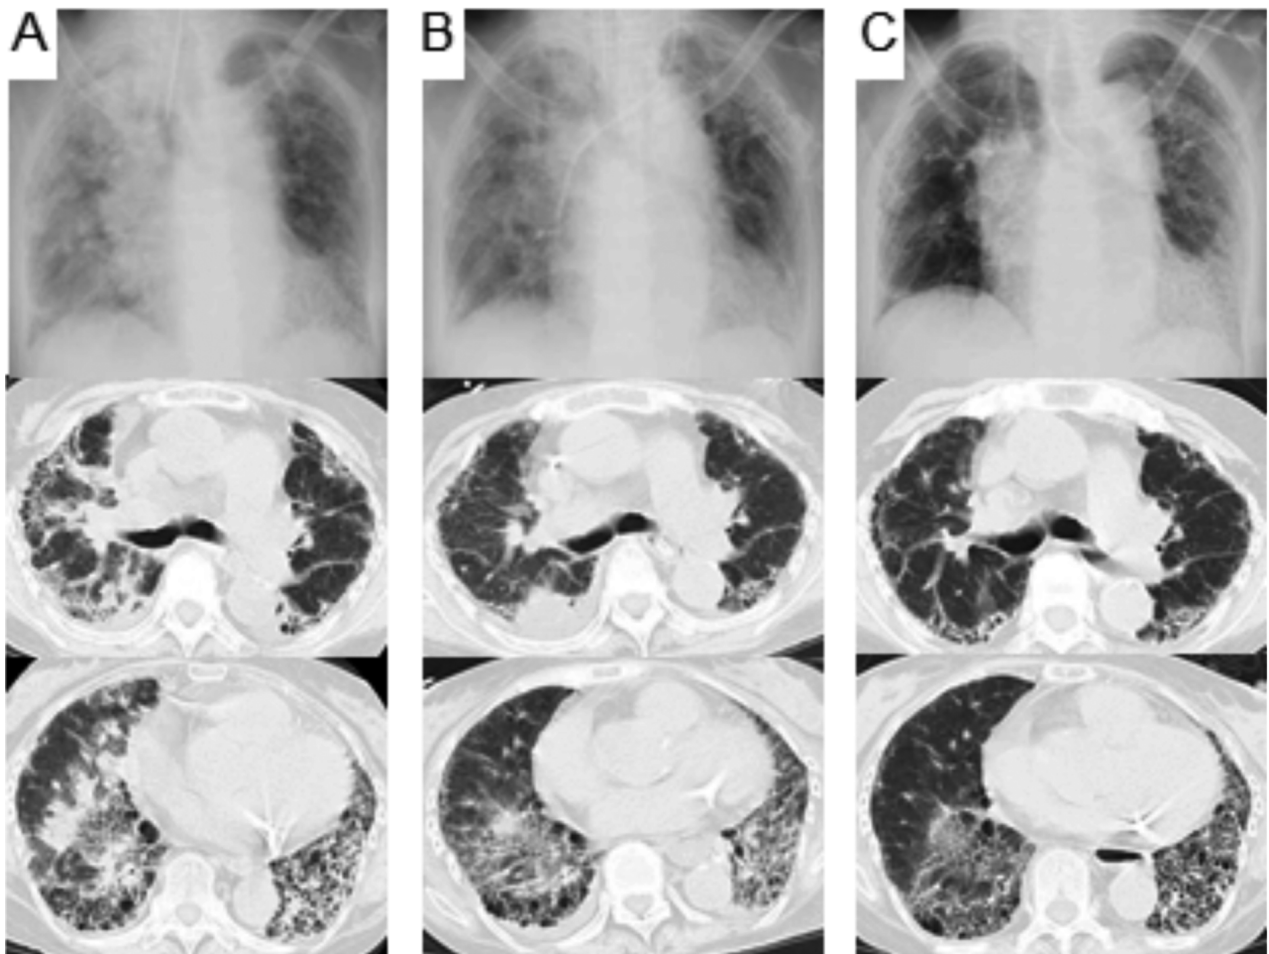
Chest radiographs and high-resolution computed tomography of patient 3 showing bilateral diffuse ground glass abnormalities superimposed on the underlying honey-combing change on admission (A) and on the 6th day (B) and on the 13th day (C)
